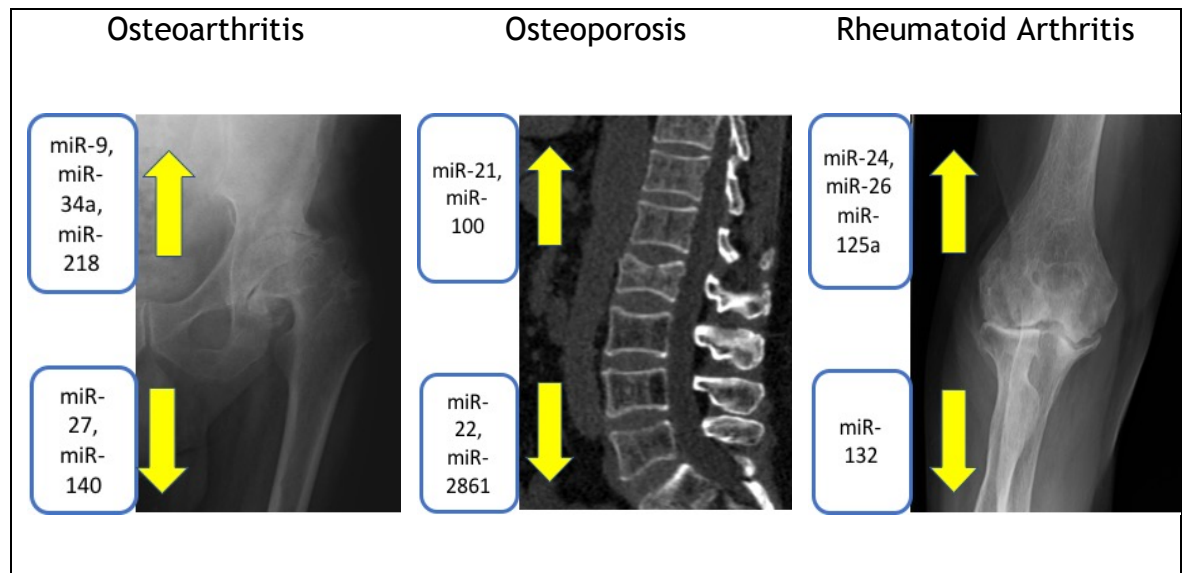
Radiographs of three common musculoskeletal diseases and some commonly reported dysregulated miRNAs known to be involved in the specific disease pathogenesis. Yellow arrows depict up or downregulation of the expression of the microRNA within the disease (Li *et al.*, 2009; Murata *et al.*, 2013; Kim and Lim, 2014; Nugent, 2016; Liu *et al.*, 2019).
